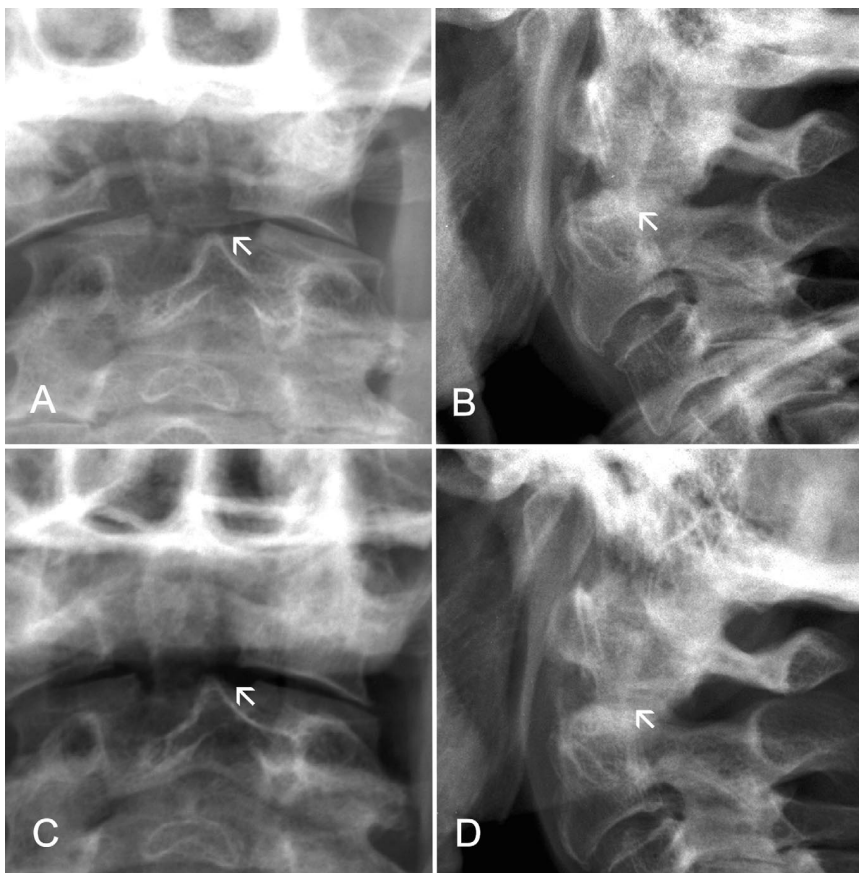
Conventional radiograph: Preoperative, a.p. (A) and lateral (B). Follow-up radiograph after 12 weeks, a.p. (C) and lateral (D). Based on the conventional radiographs, the observer can assume that bone consolidation has commenced.
